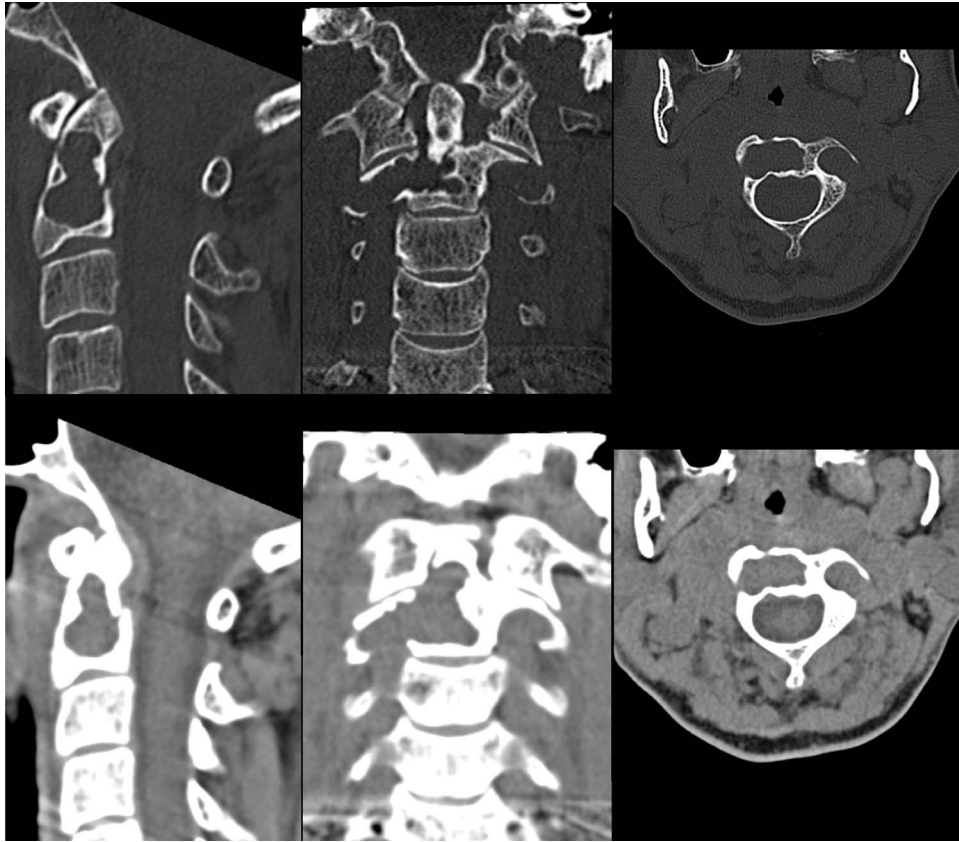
Noncontrast CT of the cervical spine shows the extended bone destruction likely on the ground of preexisting AV malformation.
